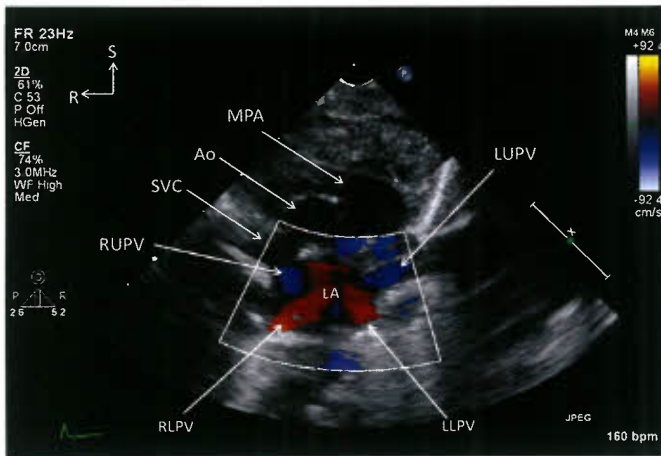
Suprasternal notch short-axis view with color Doppler demonstrating the four pulmonary veins draining normally into the left atrium. Ao, ascending aorta; LA, left atrium; LLPV, left lower pulmonary vein; LUPV, left upper pulmonary vein; MPA, main pulmonary artery; RLPV, right lower pulmonary vein; RUPV, right upper pulmonary vein; R, right; S, superior; SVC, superior vena cava.
